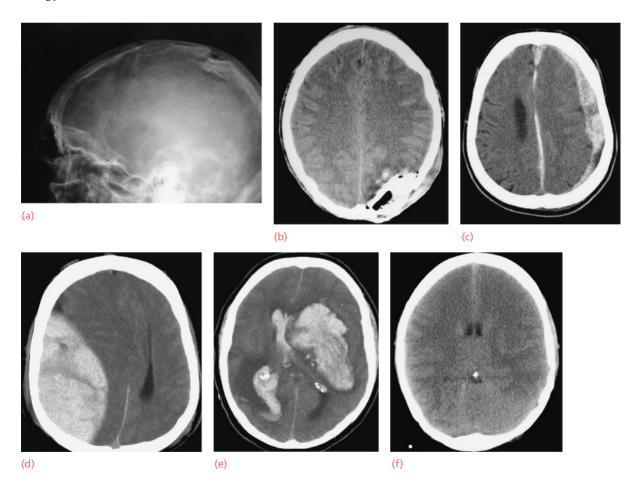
Fractured skull – imaging (a) X-ray showing a depressed fracture of the skull. (b–f) CT scans showing various injuries: (b) a fracture; (c) a subdural haematoma; (d) an extradural haematoma and compression of the left ventricle; (e) an intracerebral haematoma; (f) diffuse brain injury with loss of both ventricles.
